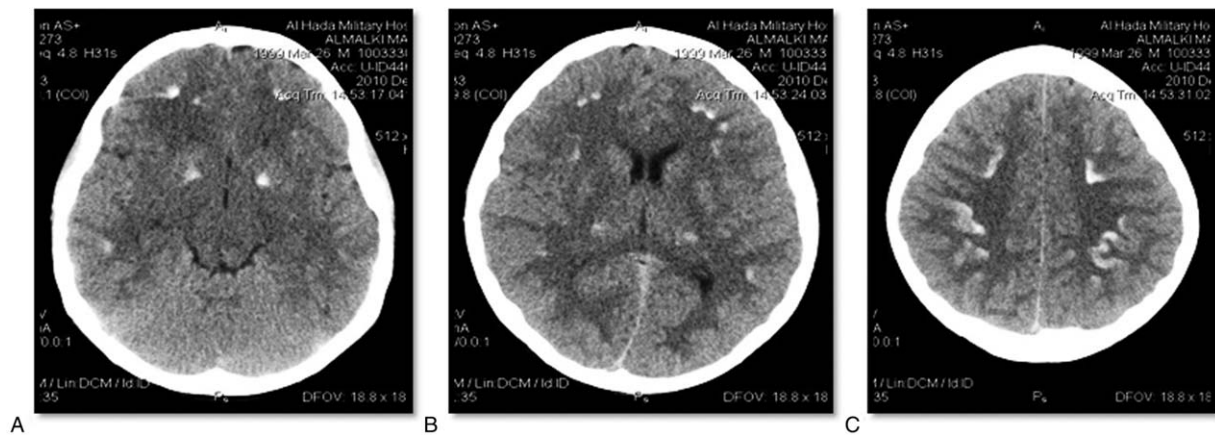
CT brain showing dense calcification in the head of caudate nucleus, basal ganglia, and the subcortical white matter region bilaterally in the cerebral cortex.
